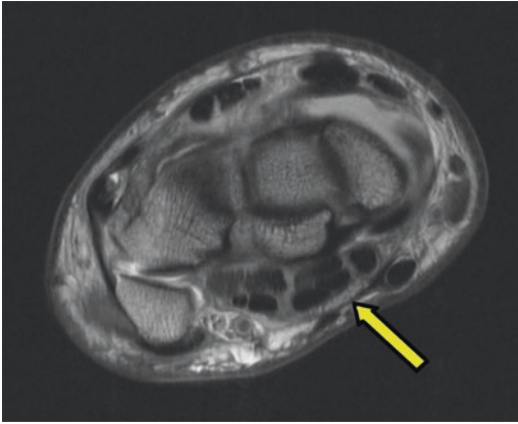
Axial MRI PD—flattening of the median nerve (*yellow arrow*) at the level of the pisiform
